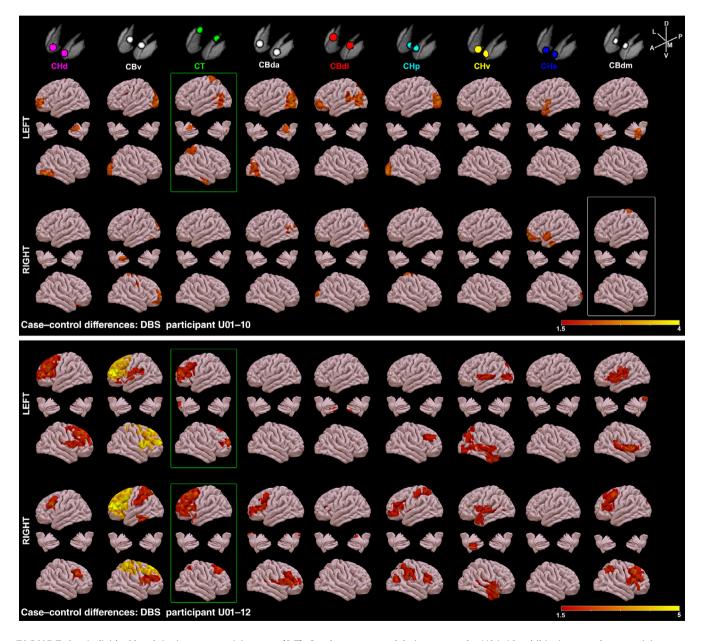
Individual level tinnitus connectivity maps (3 T). Caudate neuromodulation responder U01-10 exhibits increased connectivity between left CT and tinnitus networks of cerebellar/temporal regions, in alignment with the cohort level expectation map (Figure 1).
